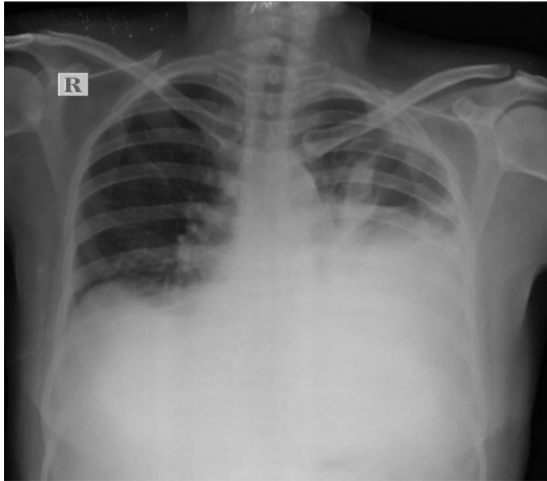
Chest X-ray showing B/L pleural effusion (L>R).
